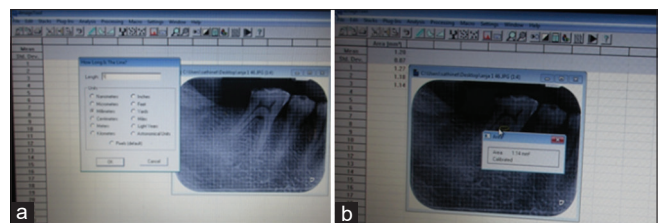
(a) Calibration of grid. (b) Measurement of area of radiographic furcation defect.
